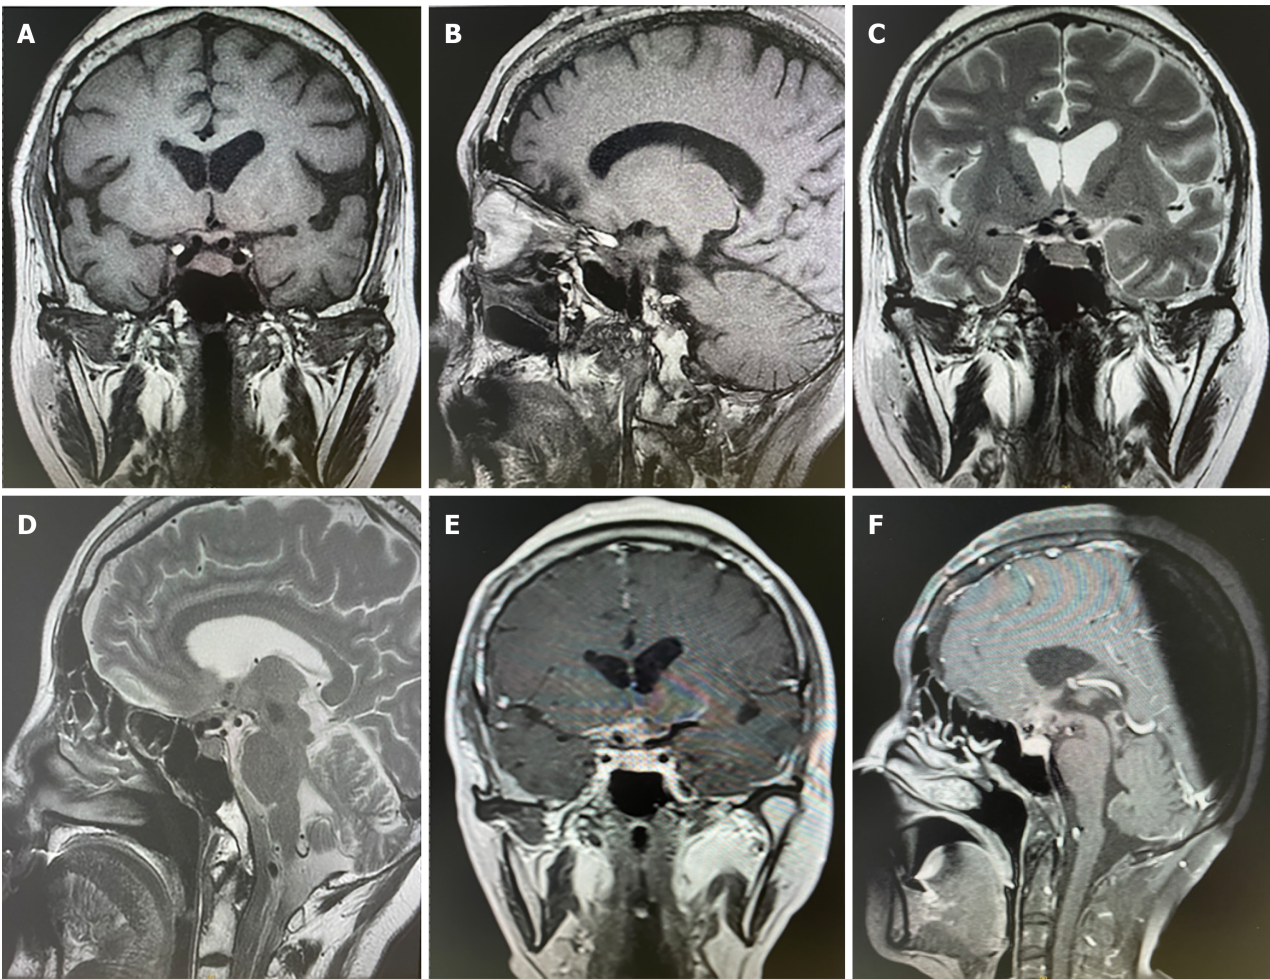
Sellar magnetic resonance imaging showed no neoplasm recurrence in 3 months after surgery. A-D: Postoperative changes of sellar region and there was no lesion found in T1 and T2-weighted images; E and F: There was no intensified lesion imaging after contrast magnetic resonance imaging.
